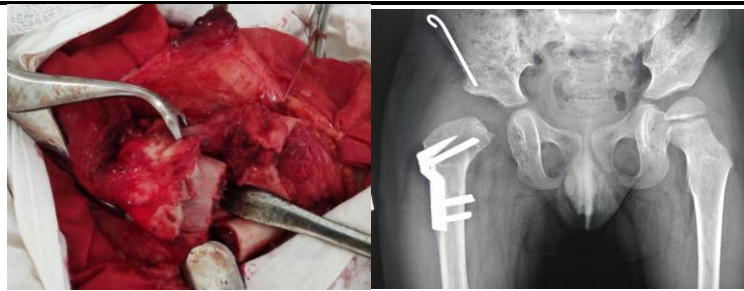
Intraoperative presentation and radiograph of the hip joints: open reduction of the femoral head and neck stump with intertrochanteric detorsion-varus and femoral neck lengthening osteotomy of the femur and Pemberton acetabuloplasty.
